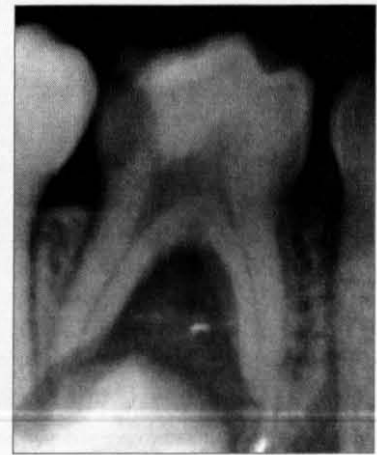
Initial periapical radiograph showed dental caries extending to the distal pulp horn and a furcation radiolucency.
